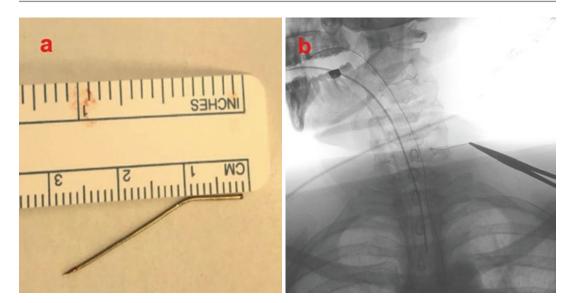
(a) Curved metallic needle averaging about 3 cm in length with one beveled end. (b) The X-ray image showed the forceps caption of the needle during its extraction
